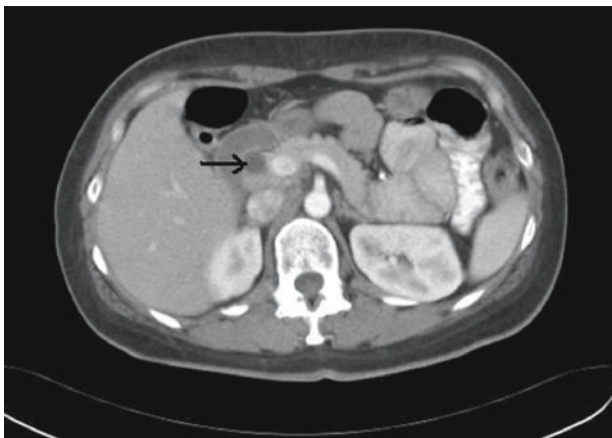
Computed tomography of the abdomen demonstrating a dilated common bile duct (arrow).
